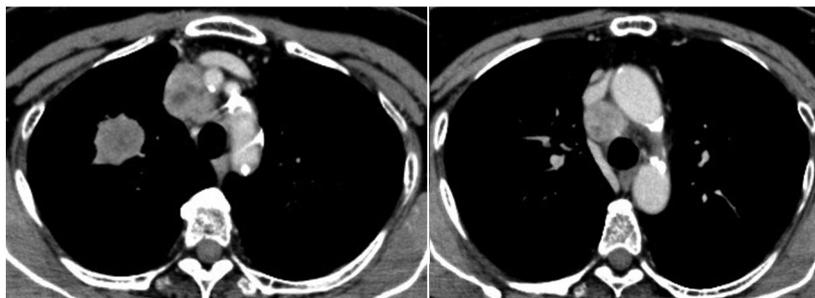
Chest computed tomography scan taken at the time of reference revealed a mass in the right middle lobe with ipsilateral mediastinal lymph node swelling.
